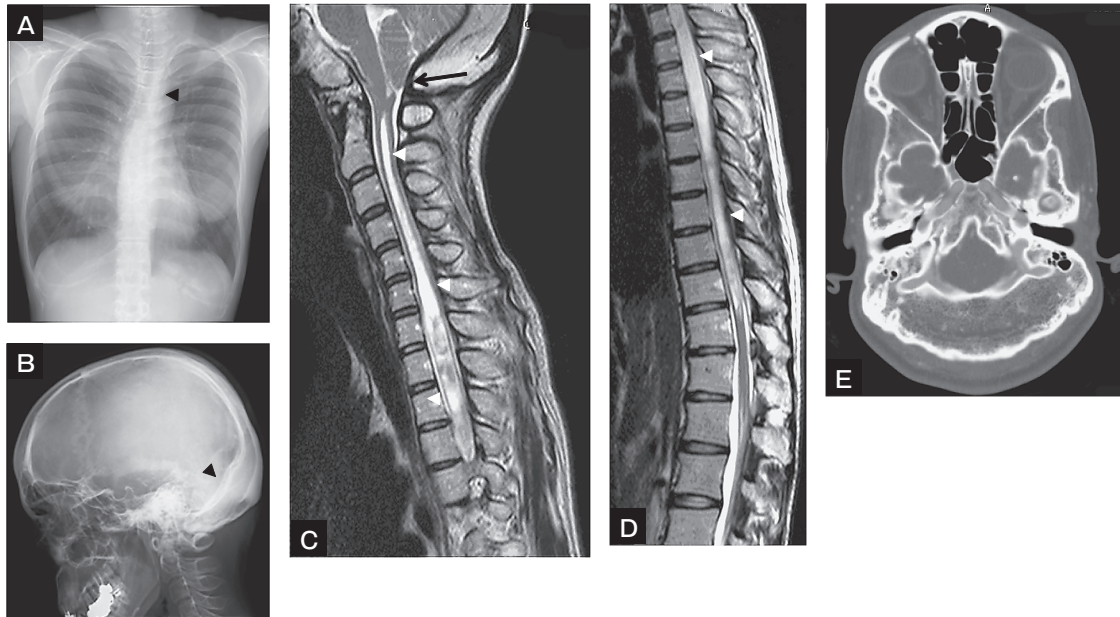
Neuroradiological images demonstrating CM with thick occipital bone. Chest X-ray demonstrated mild scoliosis (arrowhead, A). A lateral view of the skull X-ray demonstrated hyperostosis of the cranium, especially at the occiput (arrowhead, B). T2-weighted images on MRI clarified the herniation of tonsils (black arrow) and syrinx formation (white arrowheads, C, D). Enhanced CT demonstrated well-developed marginal and occipital sinuses with a narrow posterior fossa due to an extraordinarily thick occipital bone (E).
